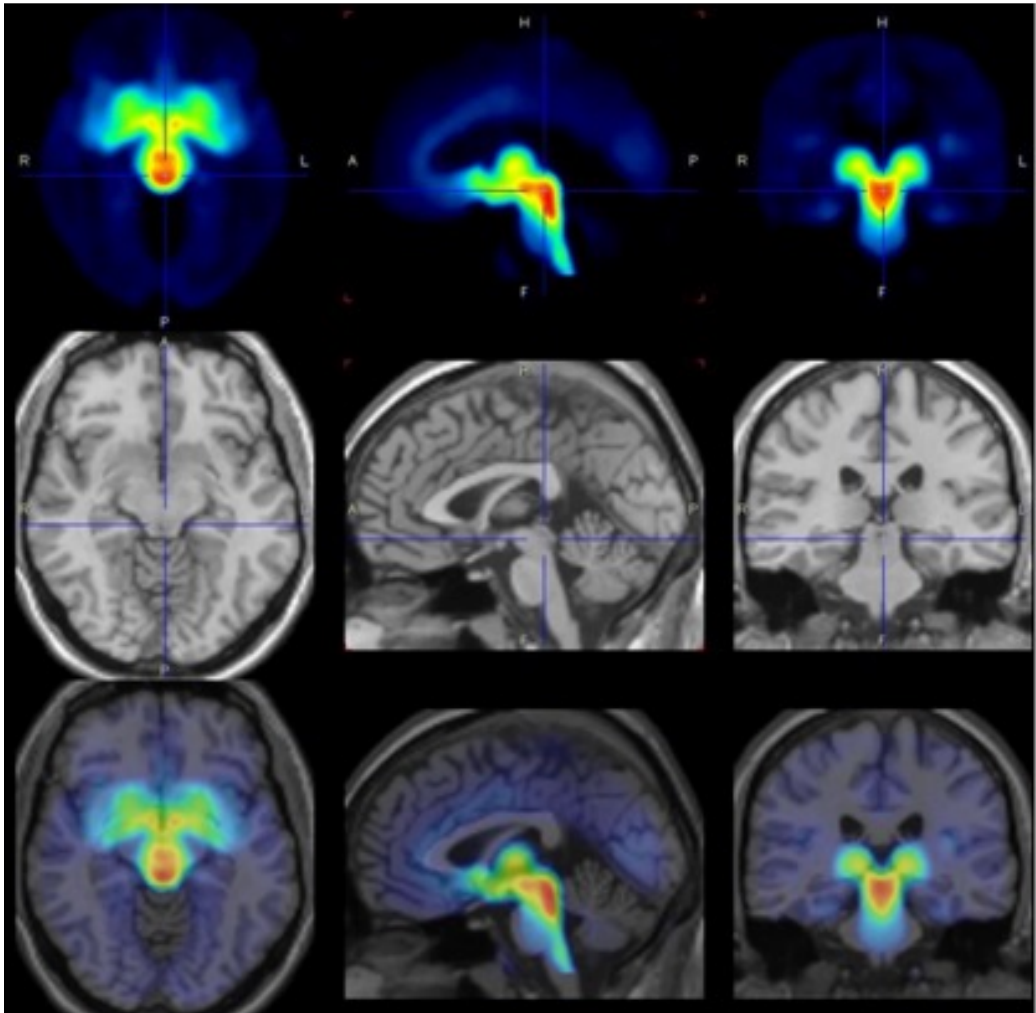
Molecular neuroimaging of serotonin transporter binding. Serotonin transporter (5-HTT) expression patterns by radiotracer ¹¹C-DASB binding obtained by dynamic positron emission tomography (PET) in living human brain across the menstrual cycle in coronal, sagittal and axial view (top panel) and structural Magnetic Resonance Imaging (MRI) scan in same individual (core panel) are displayed in overlay (bottom panel). We are the first to use this quantitative in-vivo method in a longitudinal design in patients and healthy women across the menstrual cycle.
